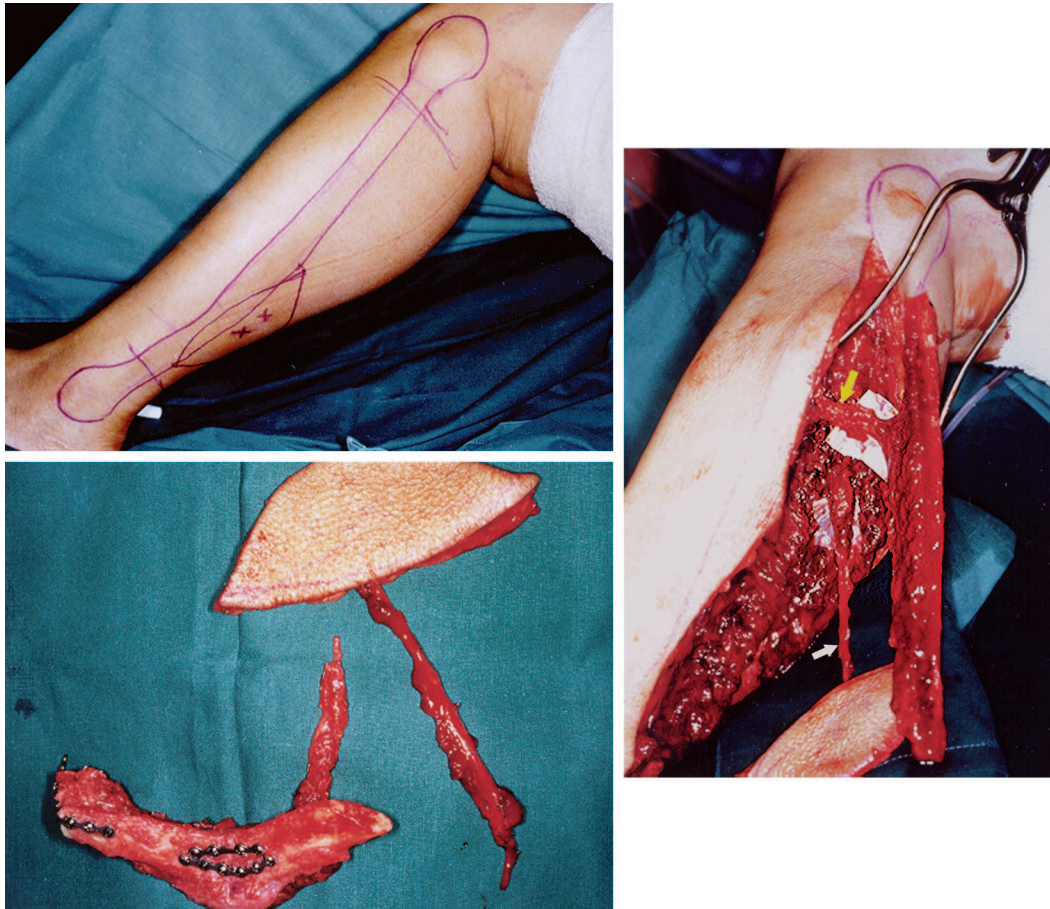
(Above, left) Skin markings for the fibula osteocutaneous flap with a distally sited skin island. Preoperative Doppler assessment detected two good-quality sounding skin perforators. (Right) No septocutaneous perforator was seen in the posterior crural septum intraoperatively. Instead, a significantly sized musculocutaneous perforator was noted. This was traced intramuscularly for a distance of 12 cm up to its origin at the tibioperoneal trunk (white arrow, soleus musculocutaneous perforator; yellow arrow, peroneal artery). (Below, left) A skin paddle was raised as a perforator flap and revascularized as a second free flap.
